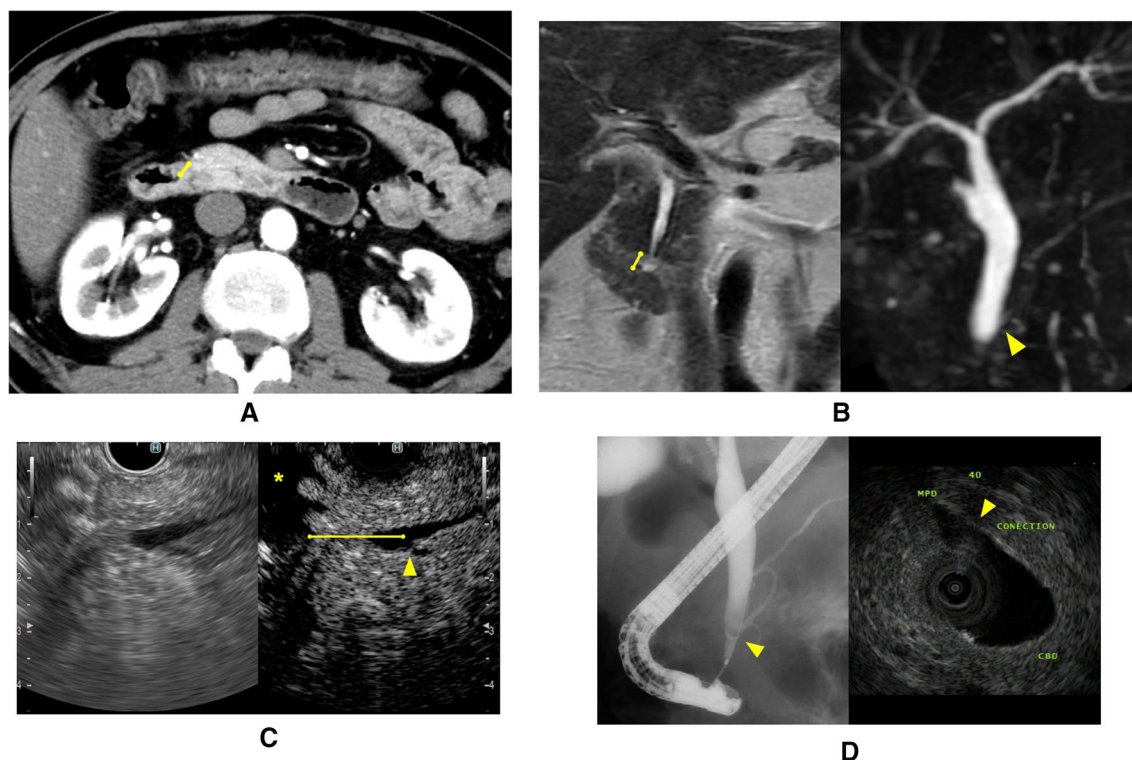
a CE-CT image. The common channel within the duodenal wall measured 4.8 mm in length (yellow line). b MR T2-weighted (left side) and MRCP (right side) images. The common channel within the duodenal wall measured 7.4 mm in length (yellow line). MRCP also showed the confluence of the pancreatic and biliary ducts (arrowhead). c CH-EUS image (left side; monitor mode, right side; contrast mode). The duodenal lumen (*) was clearer in contrast mode
